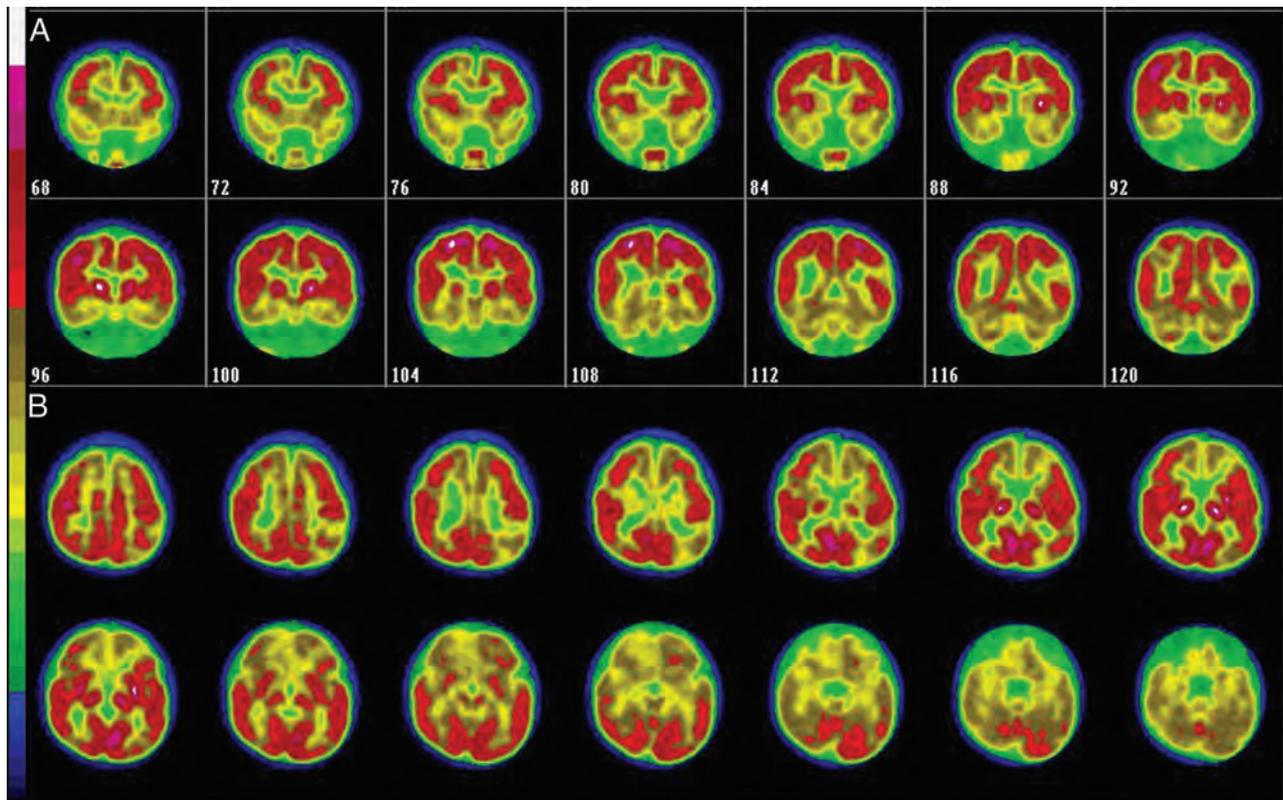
Coronal (A) and axial (B) cerebral ^{18}F -FDG PET images of a 9-month-old infant with tuberous sclerosis show multiple hypometabolic areas in the frontal and temporal cortex. Courtesy of Prof. Eric Guedj, CHU Timone, Marseille, France.
